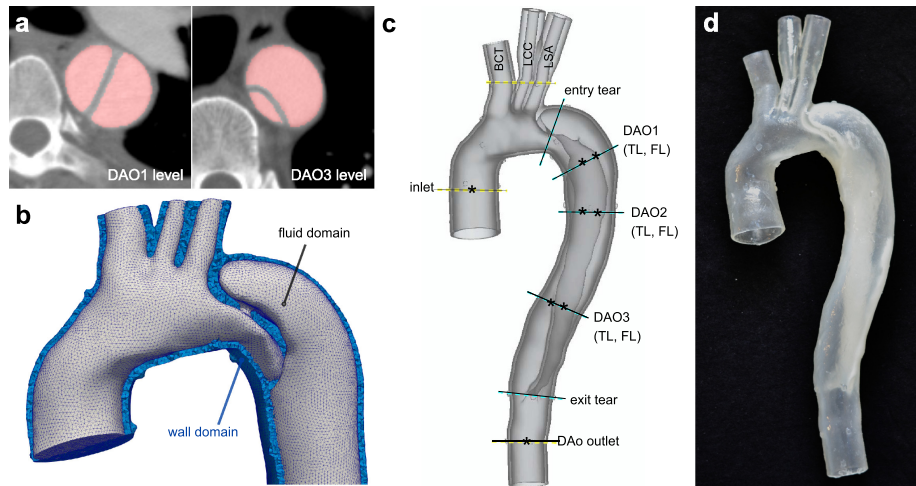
(a) CTA images with lumen segmentation. (b) Tetrahedral meshes of fluid (gray) and wall domains with dissection flap (blue). (c) Cross-sectional landmarks and pressure mapping points (*). ‘Entry’ and ‘exit’ tear cover sections with combined TL and FL flow. Landmarks DAO1, DAO2, and DAO3 consist of a TL and FL cross-section. (d) Photograph of finished 3D-printed model. (Color figure online)
